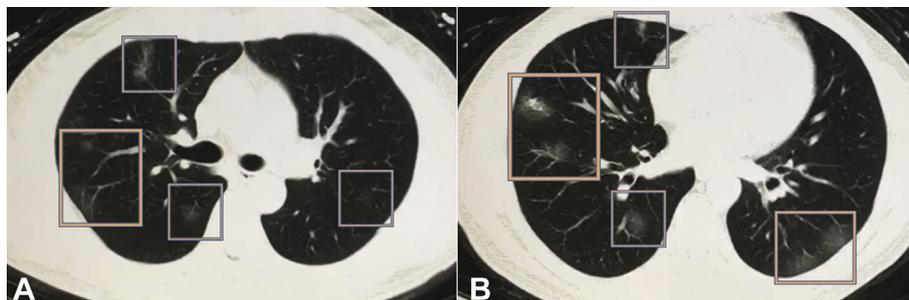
Chest CT scan from a 50-year-old male Chinese patient with a confirmed diagnosis of novel COVID-19-infected pneumonia. The patient presented with low-grade fever, cough, sneezing, fatigue, and lymphopenia. Multiple peripheral ground-glass opacities are present in both lungs (predominant on the right side), with a subpleural distribution. Imaging findings are nonspecific and might be seen with other viral pneumonias as well. Images are courtesy of Min Liu, MD, Department of Radiology, China-Japan Friendship Hospital (Beijing, China).
